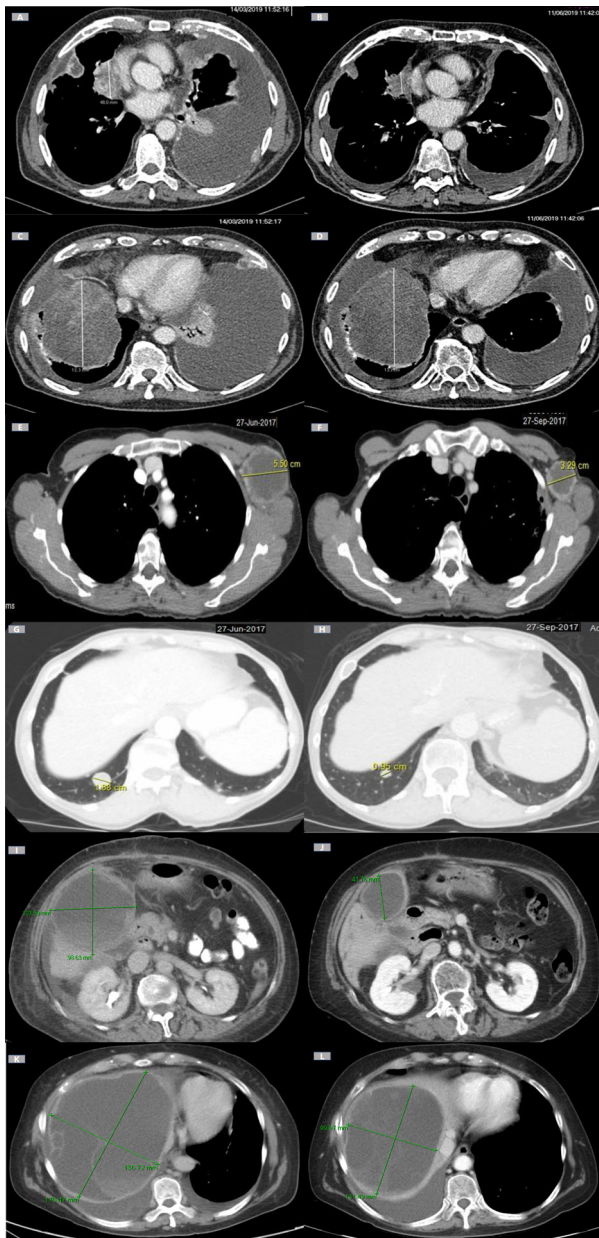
Representative images demonstrating response. (A): Baseline computed tomography (CT) scan of the first target lesion (patient 3). (B): Reduction in the tumor size after 3 months of selinexor by 40% according to RECIST version 1.1, with an increase in the necrotic component estimated at around 50%. (C): Baseline CT scan of the second target lesion (patient 3). (D): Slight dimensional increase in the second target lesion in the order of 1 cm with an increase in the necrotic-colligative component estimated at around 45% after 3 months of selinexor. (E): Baseline CT scan of the first target lesion (patient 1). (F): Decrease in the first target lesion size 45% according to RECIST 1.1 with an increase in the necrotic component estimated at around 32.7%. (G): Baseline CT scan of the second target lesion (patient 1). (H): Decrease in the second target lesion size 49% according to RECIST version 1.1. (I): Baseline CT scan of the first target lesion (patient 8). (J): Decrease in the first target lesion size 56% according to RECIST 1.1. (K): Baseline CT scan of the second target lesion (patient 8). (L): Decrease in the second target lesion size 35% according to RECIST version 1.1.
